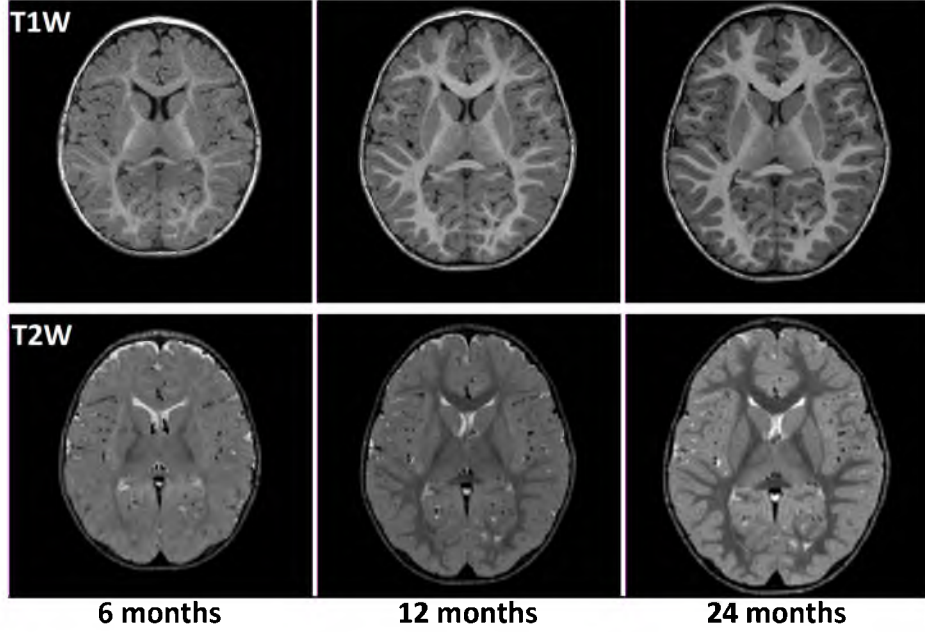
T1-Weighted (top) and T2-Weighted (bottom) MR images of the developing brain, scanned at 6 months (left column), 12 months (central column), and 24 months (right column) of age.
